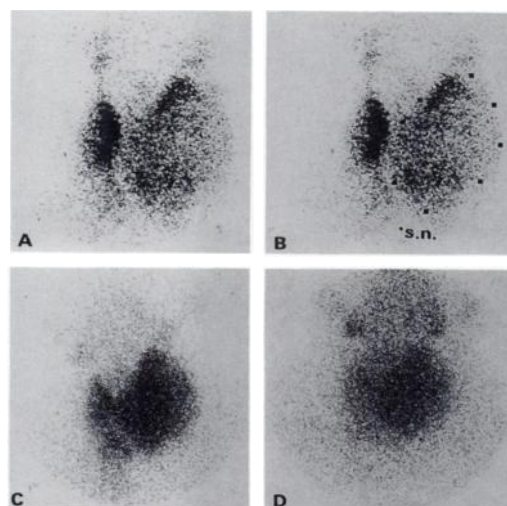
Technetium-99m and ^{201}Tl thyroid scintigraphy in a 64-yr-old female. A large cold nodule in the left lobe is visualized (A,B, s.n.-sternal notch). An increased ^{201}Tl uptake is demonstrated in the nodule as compared to the right lobe in the early as well as the late images. The visual score was +2, +2, and the L/N 1.24 and 1.28 respectively. The diagnosis was colloid nodule.
